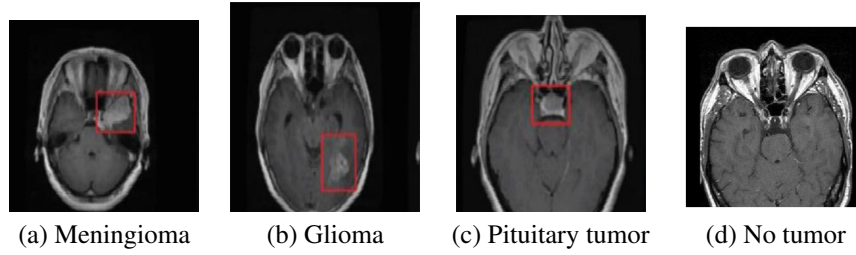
Sample of axial MRI from the dataset: (a) Meningioma, (b) Glioma, (c) Pituitary tumor, (d) No tumor
